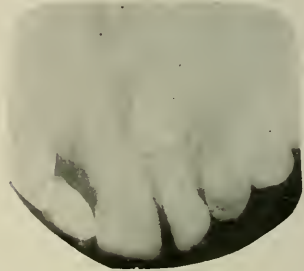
Dental radiograph made directly on bromide paper.
